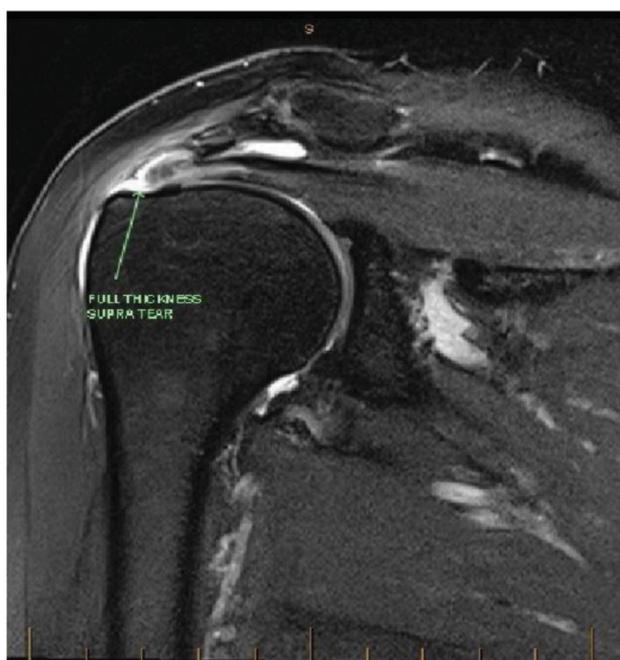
Pre-treatment MRI demonstrating full-thickness supraspinatus tear
